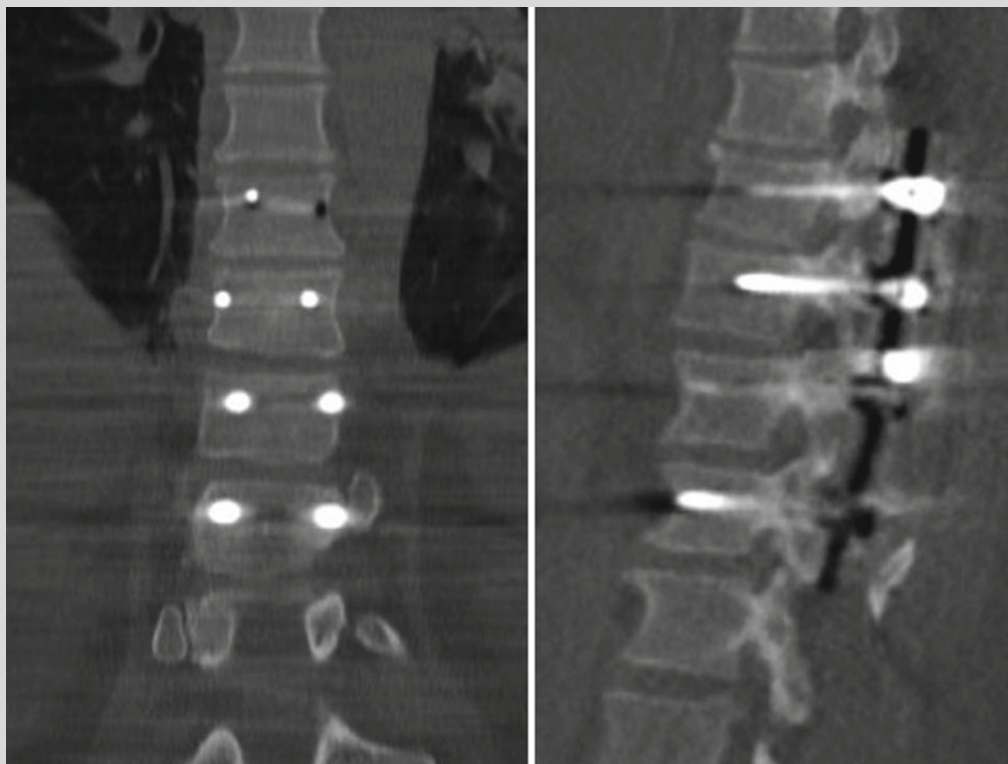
Postoperative computed tomography (CT) images demonstrate T8–11 open reduction and internal fixation with instrumented posterior spinal fusion of the T9–10 fracture-dislocation
